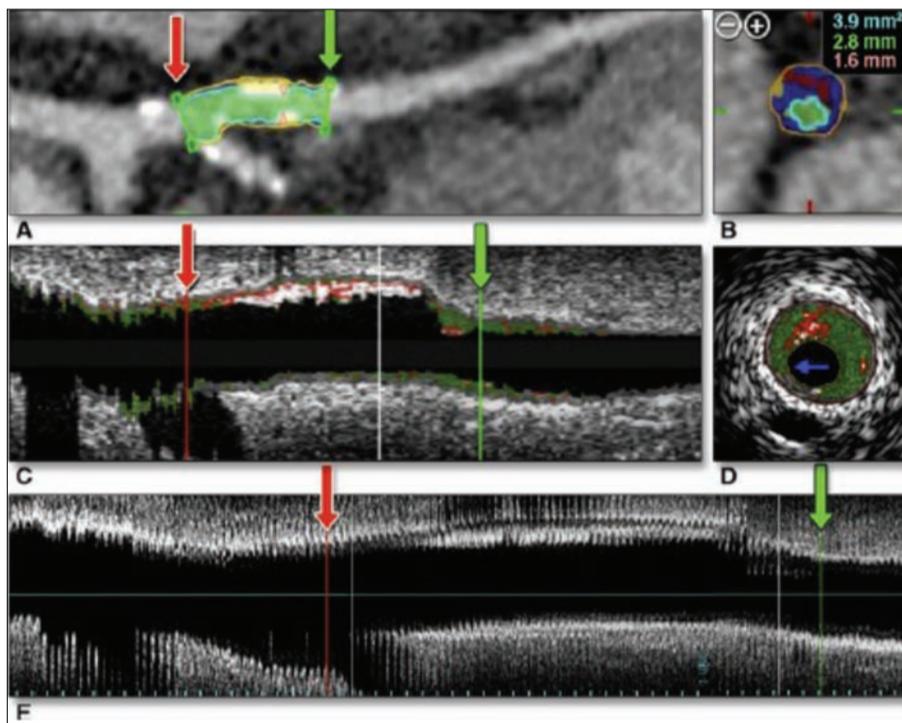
Spatially coregistered coronary CTA and IVUS/VH
